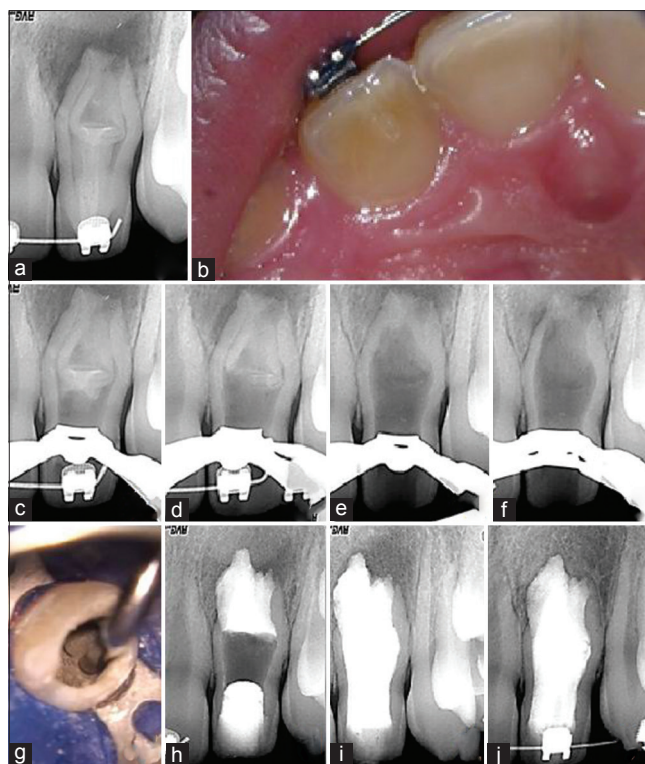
Treatment of tooth #10 (a) preoperative periapical radiograph, (b) photo of a talon cusp on the palatal surface, (c) radiograph showing dens removal from the coronal third, (d) radiograph showing dens removal from the middle third, (e) radiograph showing dens removal from the apical third, (f) radiograph showing complete removal of the invaginated tissues, (g) photo of the ProRoot MTA apical barrier placement, (h) radiograph showing MTA obturation, (i) fiber post buildup radiograph, (j) 12 months recall (Case performed by RPC)
